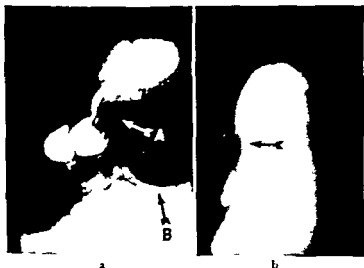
Pancreatic cyst. *a* Arteriogram view. A pressure defect is shown on the curvature of the stomach at arrow A. Note the displacement of the duodenojejunal angle with a pressure defect of the first segment of jejunum at arrow B. *b* Left lateral position showing an anterior displacement of the stomach. (Courtesy of Dr. S. Brown.) (Feldman: Clinical Roentgenology of the Digestive Tract, 2nd ed. Williams & Wilkins.)
